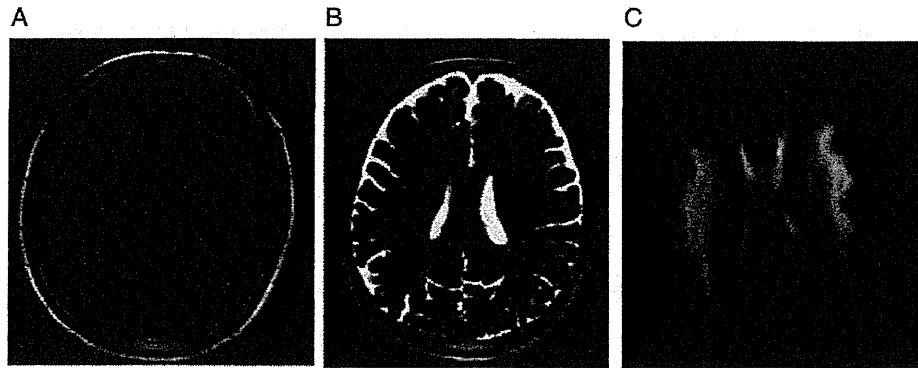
Brain magnetic resonance imaging (MRI) on the day of the onset of the symptoms. (A) No abnormal findings were detected on T1-weighted MRI (B). T2-weighted MRI faintly revealed the presence of a high signal intensity in the deep white matter of the bilateral cerebral hemispheres, including the corpus callosum. (C) In contrast, MRI-diffusion weighted imaging (DWI) clearly revealed the presence of a symmetrical high signal intensity at the same anatomical location. The value of b factor was 1000 s/mm².
